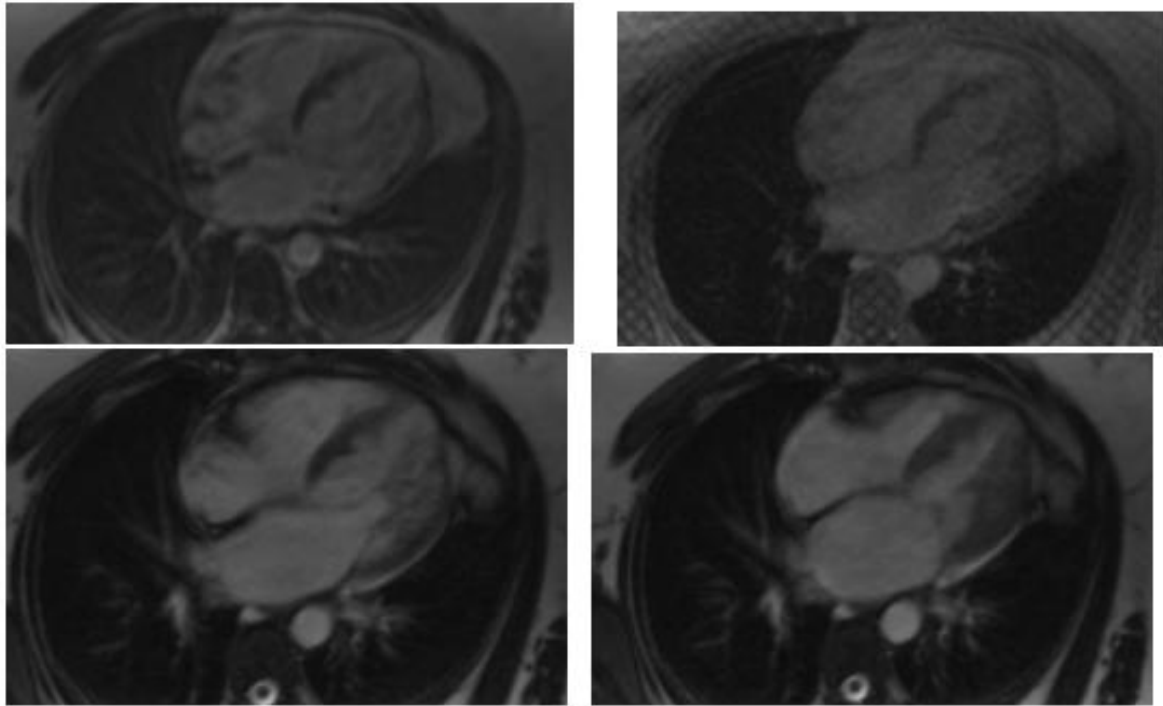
Four-chamber view of cardiac MRI revealing an LVNC (systole and diastole)
